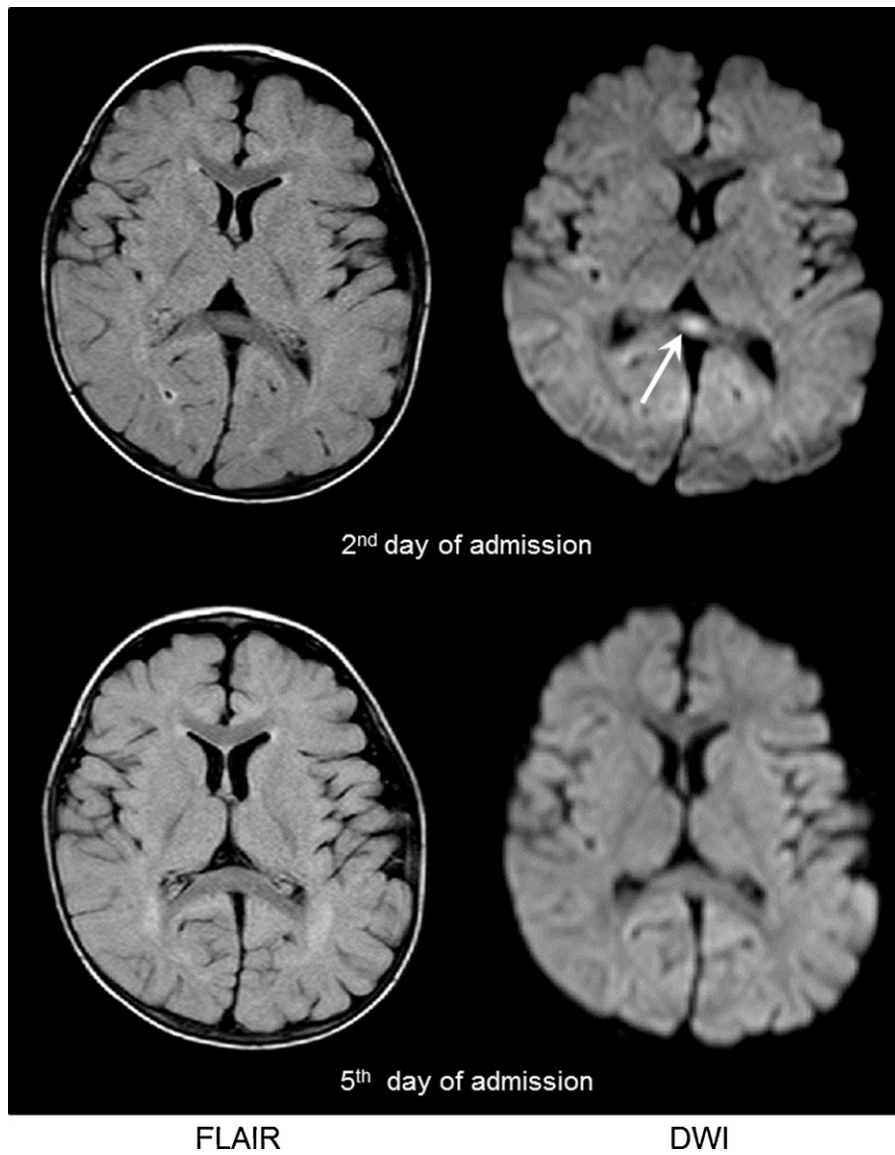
MRI findings. Top: MRI on the second day of admission DWI revealed reduced diffusion in the splenium of the corpus callosum. This lesion is unclear on FLAIR. Bottom: MRI on the fifth day of admission. No abnormal findings were observed on FLAIR or DWI. FLAIR, fluid-attenuated inversion-recovery images; DWI, diffusion-weighted images.
